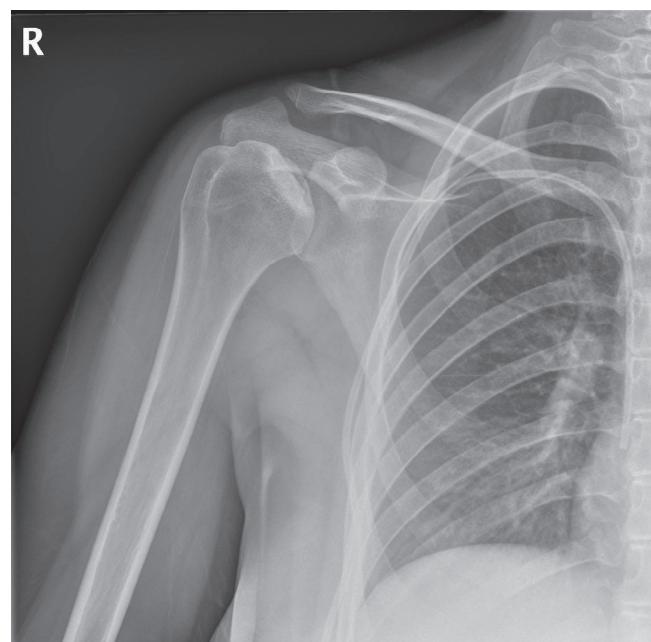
Antero-posterior X-ray of the right humerus, demonstrating flattening and sclerotic change of the right humeral head.
